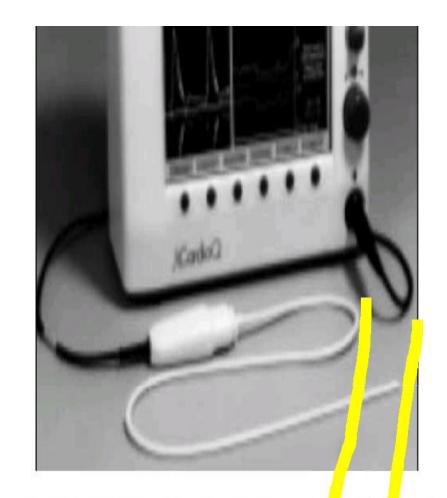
Cardio Q-Doppler shift Lased cardiac output and aortic volume me surement and display system (Courtesy: Deltex Medical IISA)
